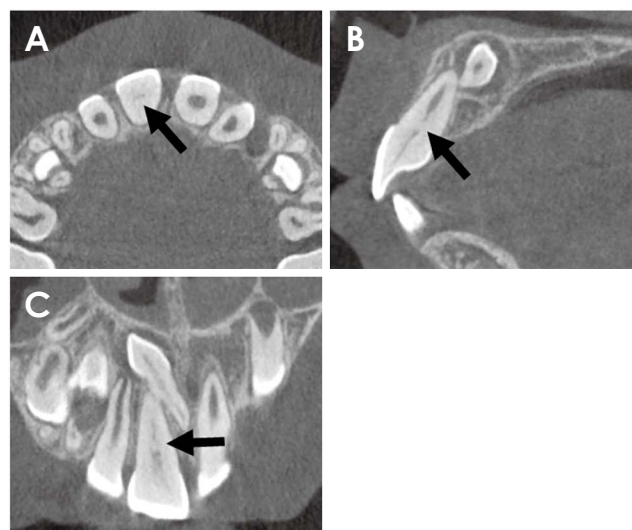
Mesiodens-related calcification of the root canal of permanent maxillary right central incisor. Note that the mesiodens is in direct contact with the apex of the root. A. Axial cone-beam computed tomographic (CBCT) image. B. Sagittal CBCT image. C. Coronal CBCT image.
